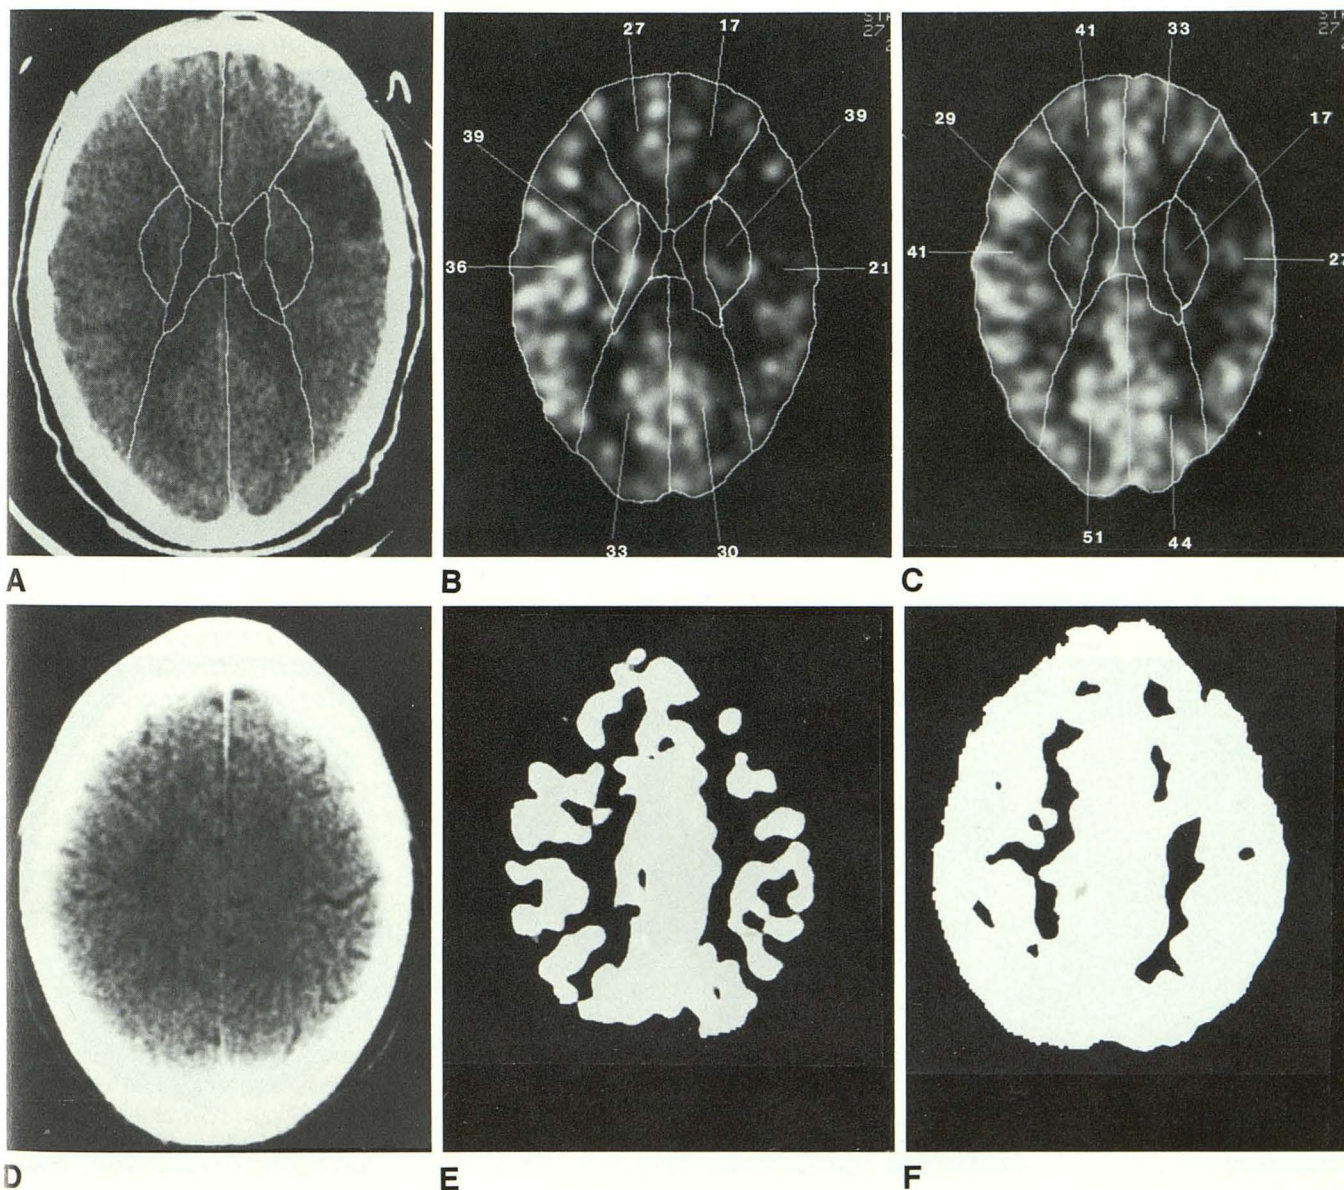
A–F, Case 28. Xe/CT scans demonstrate a representative type II scan series.
